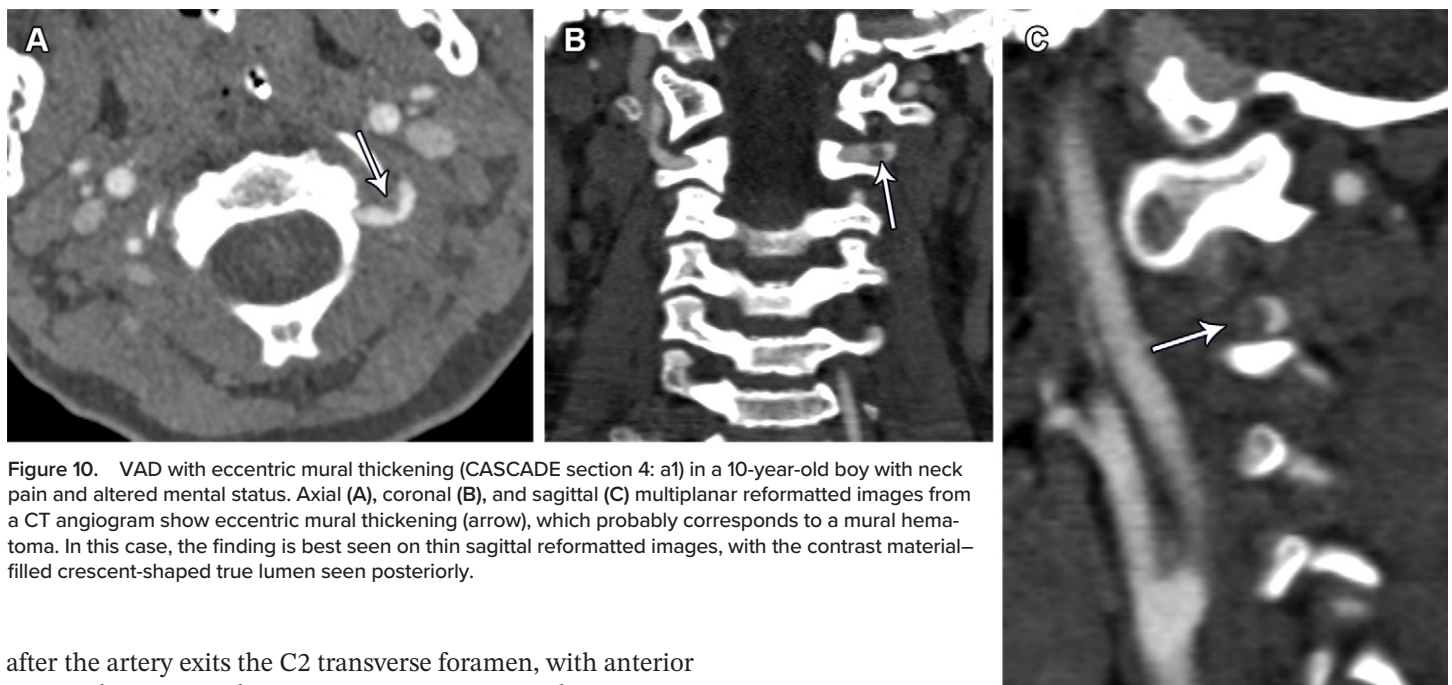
VAD with eccentric mural thickening (CASCADE section 4: a1) in a 10-year-old boy with neck pain and altered mental status. Axial (A), coronal (B), and sagittal (C) multiplanar reformatted images from a CT angiogram show eccentric mural thickening (arrow), which probably corresponds to a mural hematoma. In this case, the finding is best seen on thin sagittal reformatted images, with the contrast material-filled crescent-shaped true lumen seen posteriorly.
